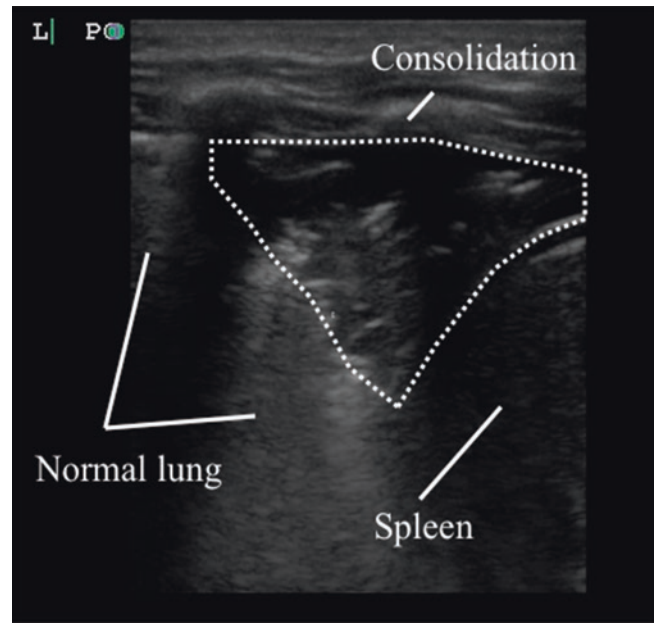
Inferior lung consolidation: sagittal view. Consolidations are often found in the inferior lung abutting the liver or spleen. This picture demonstrates the sonographic differences between lung consolidation and splenic parenchyma
